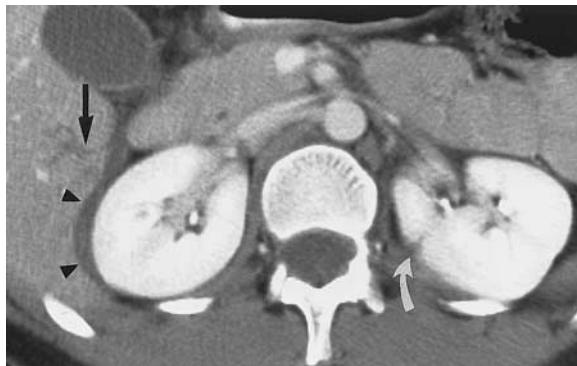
Simple renal laceration (category I) in a 30-year-old woman who had sustained blunt abdominal trauma. Contrast-enhanced multidetector helical CT scan reveals a small, hypoattenuating laceration crossing the interpolar region of the left kidney (white arrow) associated with a limited perinephric hematoma. A hepatic laceration (black arrow) and hemoperitoneum in the Morrison pouch (arrowheads) are also seen.
